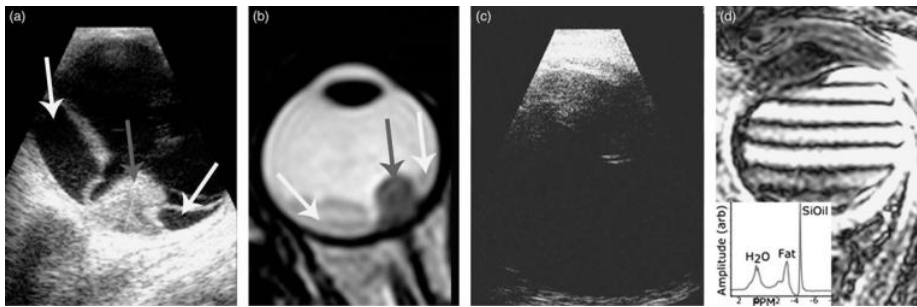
(a) Imaging using US reveals UM (grey arrow) and RD (white arrows). (b) MRI allows for a 3D evaluation of the tumour and surrounding structures. A T2-weighted image on which the tumour appears as a hypointense mass (grey arrow) with adjacent less hypointense RD (white arrows). (c) As US waves are reflected at the SiOil–water interface, US imaging is not possible in UM patients after vitrectomy, preventing accurate diagnosis or follow-up. (d) Although MRI should be possible in eyes with a SiOil tamponade, the off-resonance of the SiOil causes the conventional protocols to fail, resulting in strong artefacts. The MR spectrum of an UM patient with SiOil tamponade, showing the strong 4.5 ppm off-resonance of SiOil compared with water. The peak at 3.2 ppm is the fat signal from the orbital fat. RD, retinal detachment; SiOil, silicone oil; UM, uveal melanoma; US, ultrasound.
